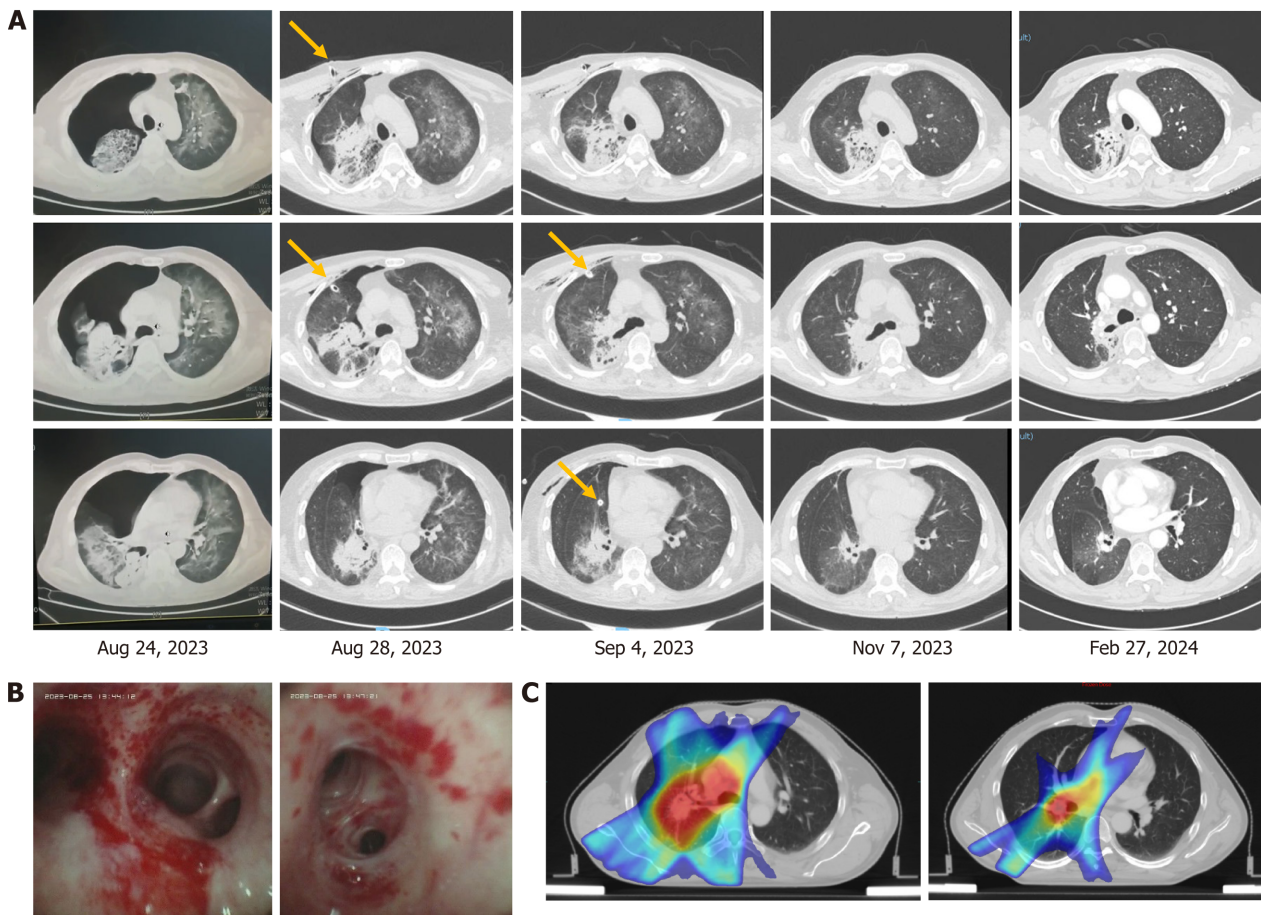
Radiographic and tracheoscopy findings. A: The computed tomography image changes before and after PJP treatment. The orange arrow shows the drainage tube. B: Tracheoscopy findings. C: Tumor irradiation field.
